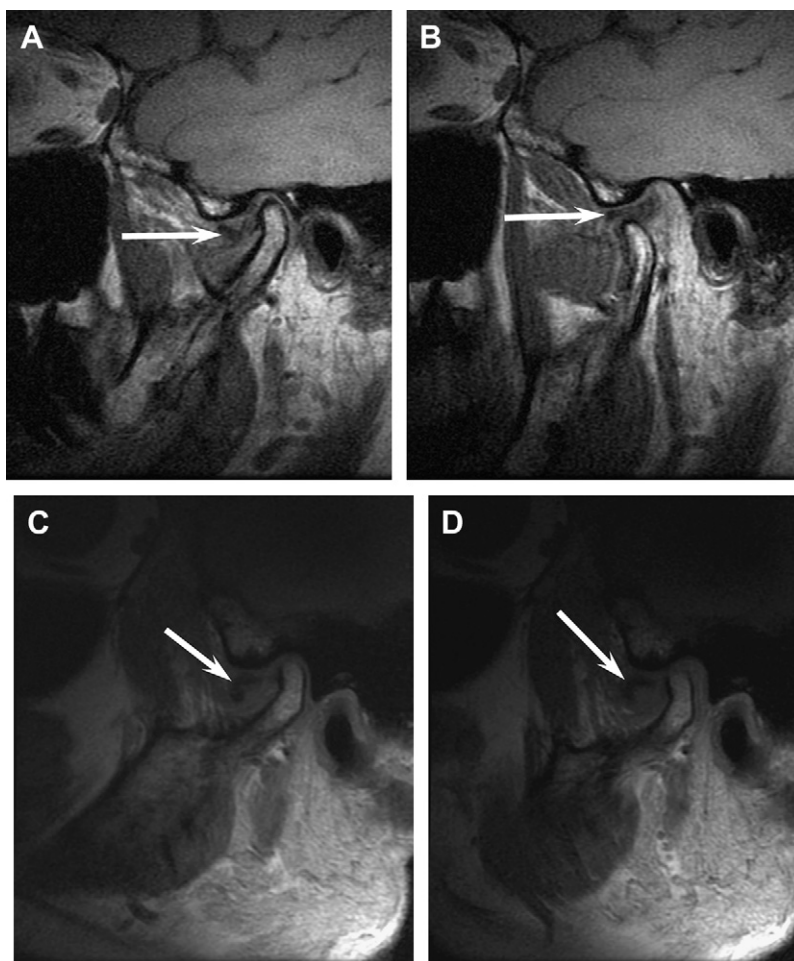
MRI for disc pathology of the TMJ. (A) Sagittal oblique T1-weighted image in closed-mouth position reveals anterior dislocation of the low-signal articular disc (arrow). (B) Sagittal oblique T1-weighted image in open-mouth position shows recapture of the dislocated disc (arrow). (C) Sagittal oblique T1-weighted image in closed-mouth position from a different patient also shows anterior dislocation of the articular disc (arrow). (D) In this second patient, the disc (arrow) remains dislocated in the open-mouth position.
